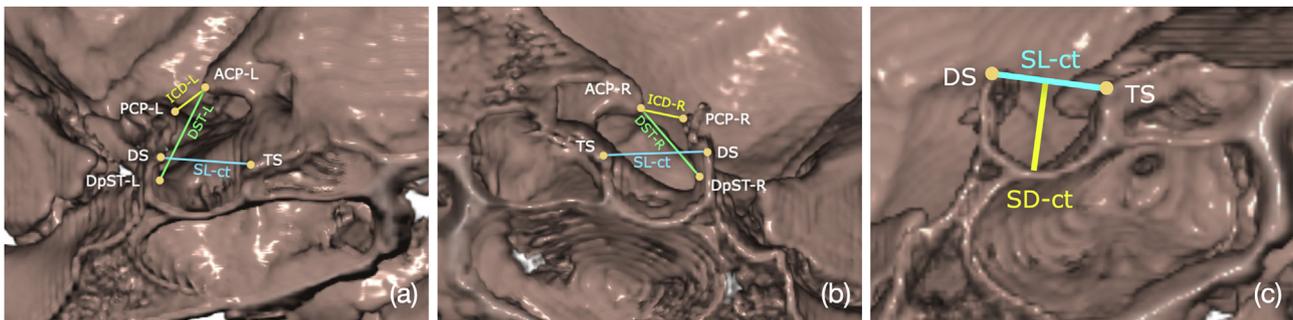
The left side view and the right side view of the sella turcica on the cranial base. The sella-turcica dimensions measured on (a) the left side view and (b) the right side view. (c) The sella length (SL) and sella depth (SD) measured on the mid-sagittal plane in CBCT. The landmarks of the sella turcica: (1) tuberculum sella (TS): the midpoint on the anterior boundary of sella-turcica identified on the midsagittal plane; (2) dorsum sella (DS): the midpoint on the posterior boundary of the sella-turcica on the midsagittal plane; (3) anterior clinoid process, right (ACP-R): the apex of the anterior clinoid process on the right side; (4) anterior clinoid process, left (ACP-L): the apex of the anterior clinoid process on the left side; (5) posterior clinoid process, right (PCP-R): the apex of the posterior clinoid process on the right side; (6) posterior clinoid process, left (PCP-L): the apex of the posterior clinoid process on the left side; (7) diameter point of sella turcica, right (DpST-R): the furthest point on the inner wall of the pituitary fossa on the right side; (8) diameter point of sella turcica, left (DpST-L): the furthest point on the inner wall of the pituitary fossa on the left side. The sella-turcica dimensions: SL-lc: sella length measured in lateral cephalogram; SD-lc: sella depth measured in lateral cephalogram; DST-lc: diameter of sella turcica measured in lateral cephalogram; SL-ct: sella length measured in CBCT; SD-ct: sella depth measured in CBCT; ICD-L: interclinoid distance-L; ICD-R: interclinoid distance-R; DST-L: diameter of sella turcica-L; DST-R: diameter of sella turcica-R; ACD: anterior clinoid distance; PCD: posterior clinoid distance.
